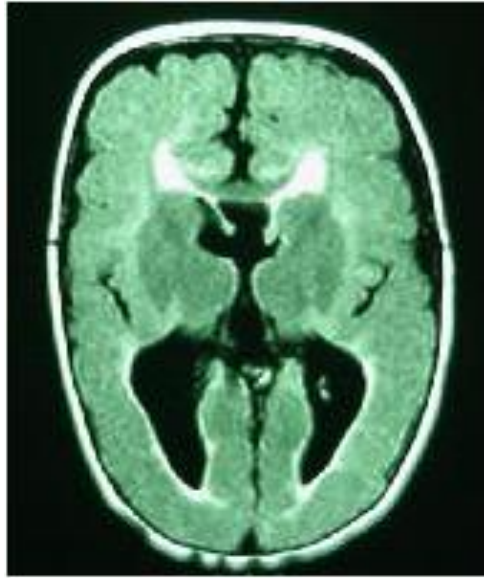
Magnetic Resonance Image (MRI) of a one-year-old boy who was born at gestational age 27 week.
